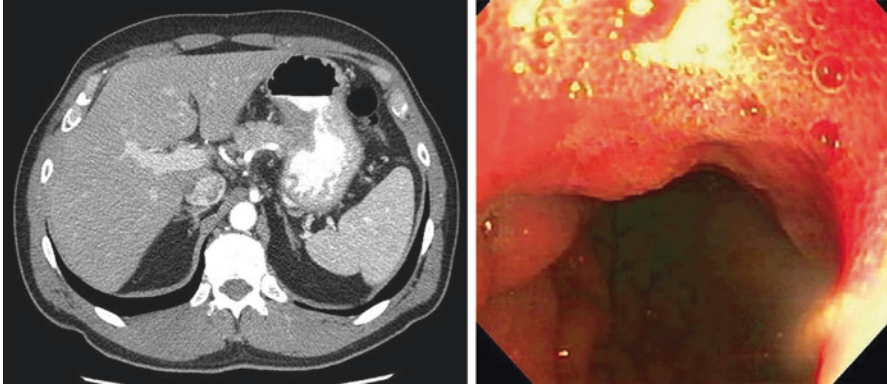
Computed tomography scan (left) and endoscopic image (right) of gastric adenocarcinoma
